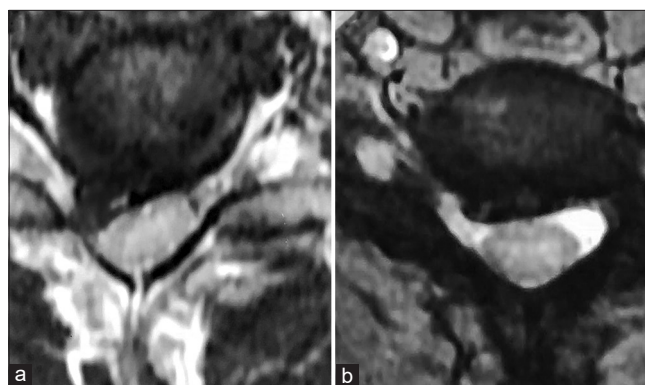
(a) MRI cervical spine, axial view, suggestive of a posterior disc extrusion at the C6-C7 level in the right paracentral location indenting the cervical spinal cord and the exiting right C7 root. (b) Follow-up MRI cervical spine, axial view, 3 months later revealed significant spontaneous regression of the C6-C7 intervertebral disc extrusion.
